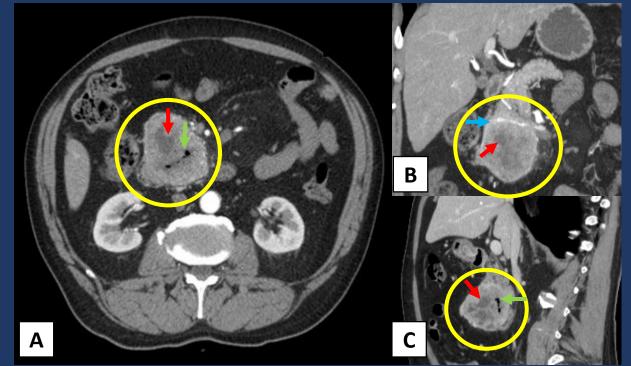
Axial (A), coronal (B) and sagittal (C) contrast-enhanced CT shows an duodenal exophytic mass (circle) with peripheral calcification (blue arrow) and heterogeneous enhancement, with central necrosis (red arrow) and central air (green arrow) suggesting fistulization, typical findings in a GIST.
